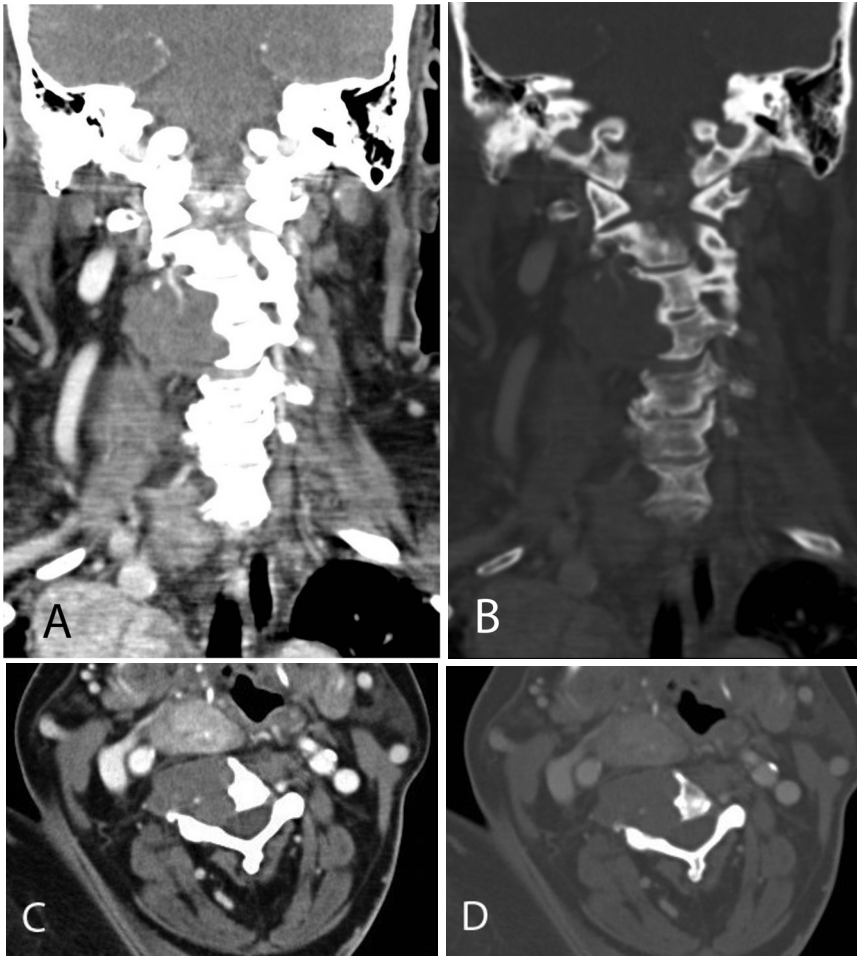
Coronal and axial contrast-enhanced CT in soft tissue and bone windows. A relatively hypodense mass encases the right vertebral artery at C3, and extends contiguously from the C3 to C4 vertebral bodies with a sclerotic, well-defined medial border in both vertebrae. The mass abuts, but does not invade the central canal, and there is no mass effect on the spinal cord.
